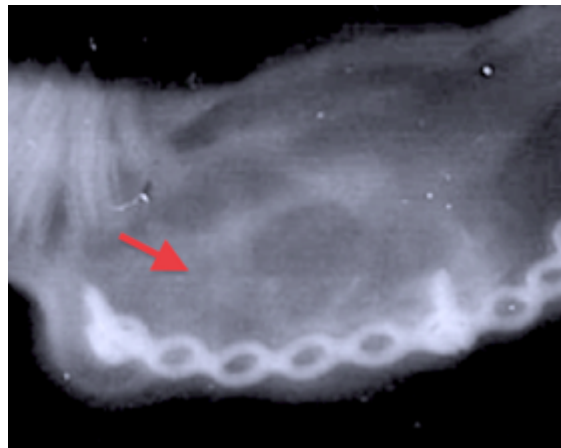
An extra-oral radiographic image taken at one month showing an island of radio-opaque tissue at the centre of the defect which is in continuity with the proximal and superior and inferior margins of the defect area (red arrows).
